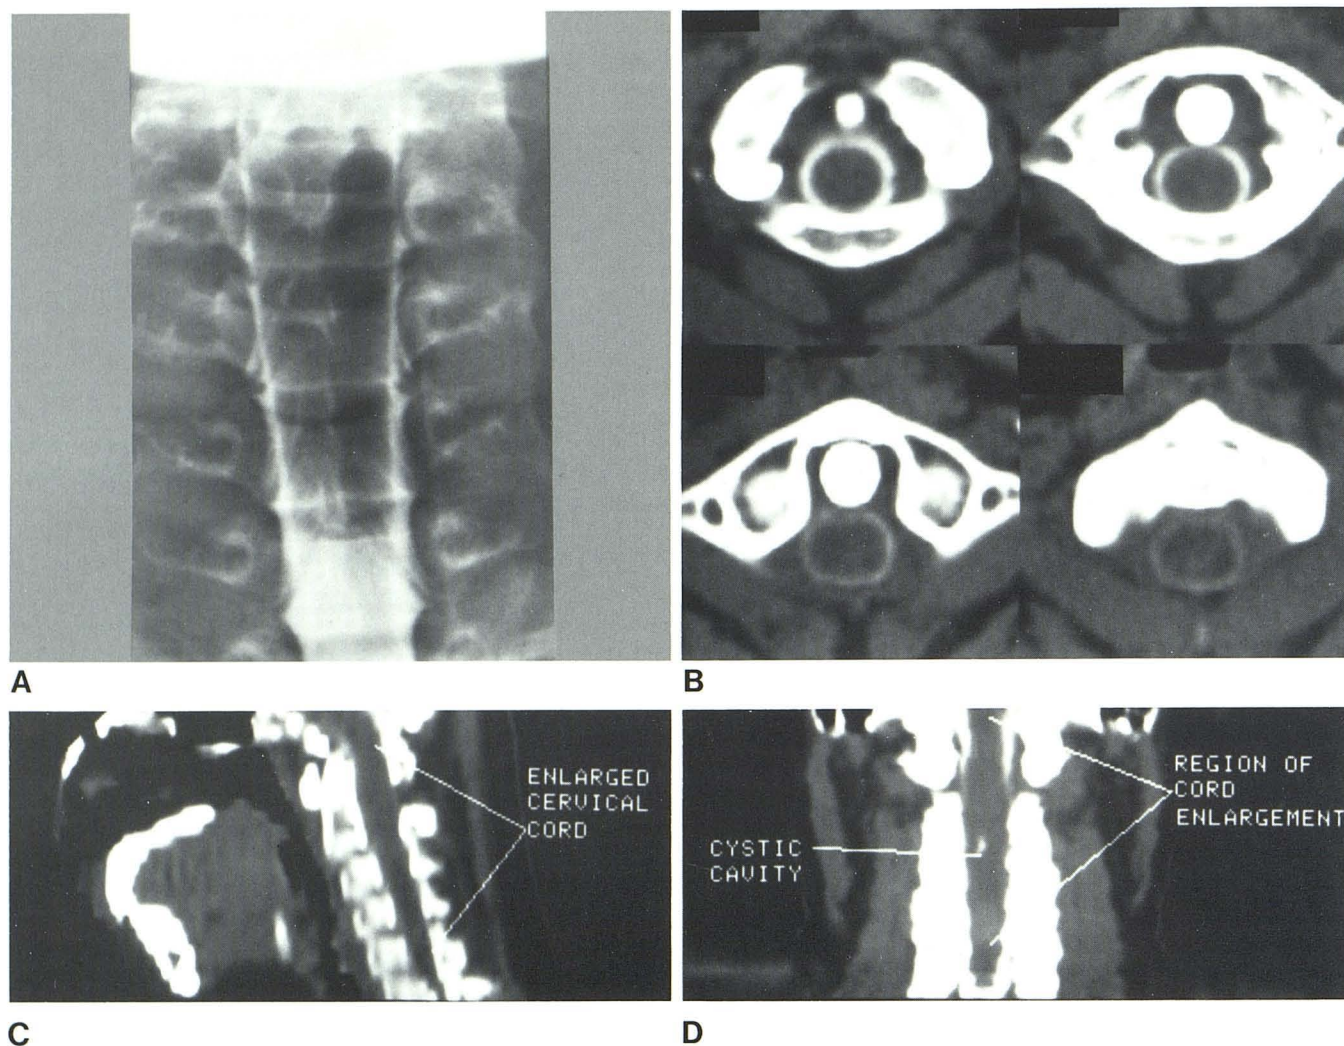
Ependymoma of cervical cord extending into lower medulla. A, Metrizamide myelogram. Fusiform widening of cervical spinal cord. Axial CT images (B) and midsagittal reformation (C) show cephalad extent of tumor to
